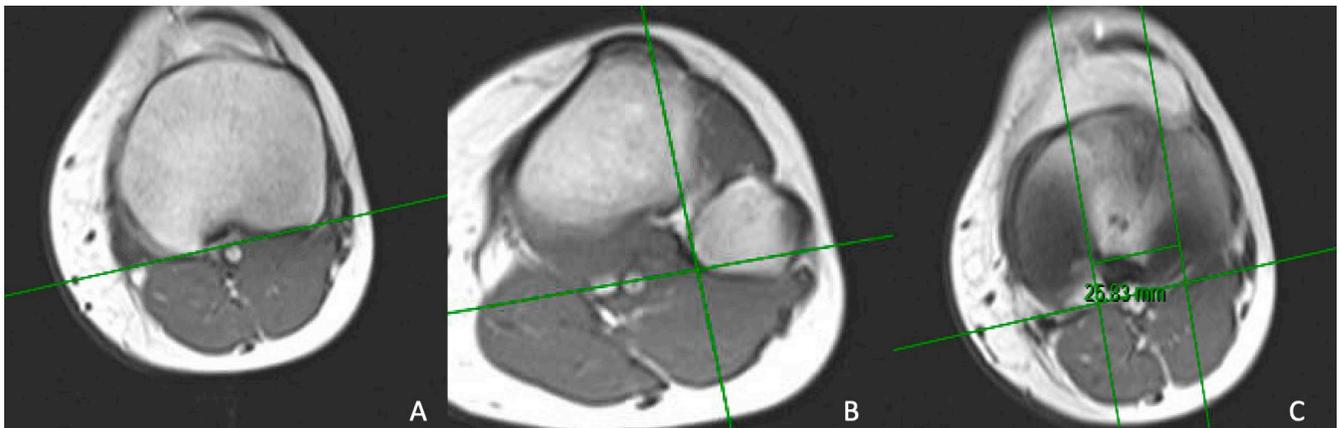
Sequential images demonstrating the measurement of tibial tubercle-posterior cruciate ligament (TT-PCL) distance (measured in millimeters, mm) on preoperative MRI. (A) Measurement of TT-PCL was made in parallel to the axis formed by the posterior tibial condyles. (B) Line drawn through the center of the anterior tibial tuberosity. (C) Parallel line drawn through the center of the insertion of the PCL. In this example, the TT-PCL distance is 25.83 mm.
